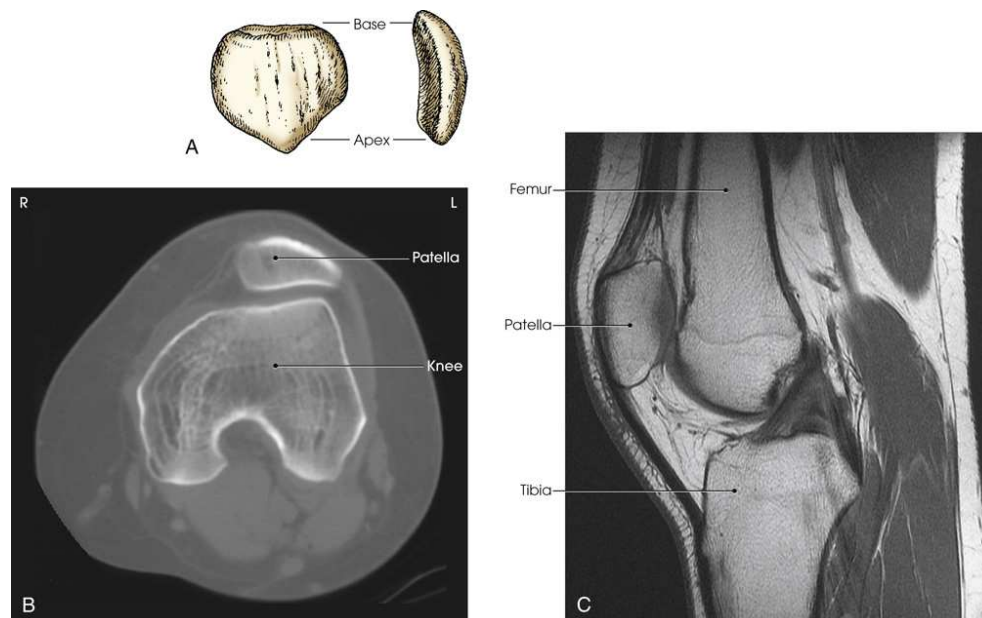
(A) Anterior and lateral aspects of patella. (B) Axial CT scan of patella showing relationship to femur. (C) Sagittal MRI showing patellar relationship to femur and knee joint. The apex of the patella is $\frac{1}{2}$ inch (1.3 cm) above the knee joint. B and C, Modified from Kelley LL, Petersen CM. *Sectional anatomy for imaging professionals*, ed 2, St Louis: Mosby; 2007.
